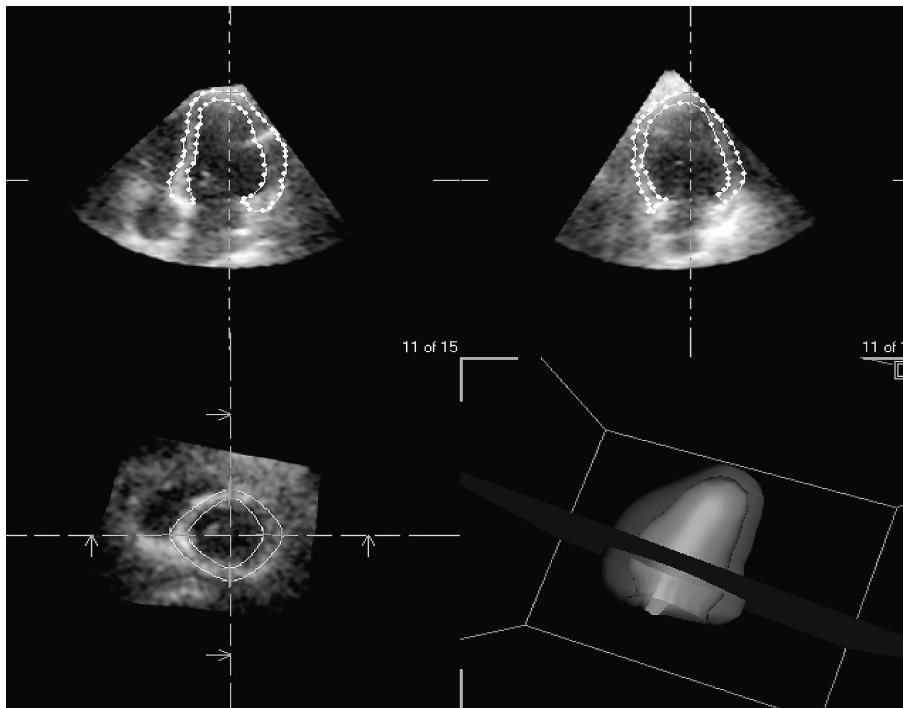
Measurement of left ventricular myocardium volume from real-time three-dimensional echocardiographic images
